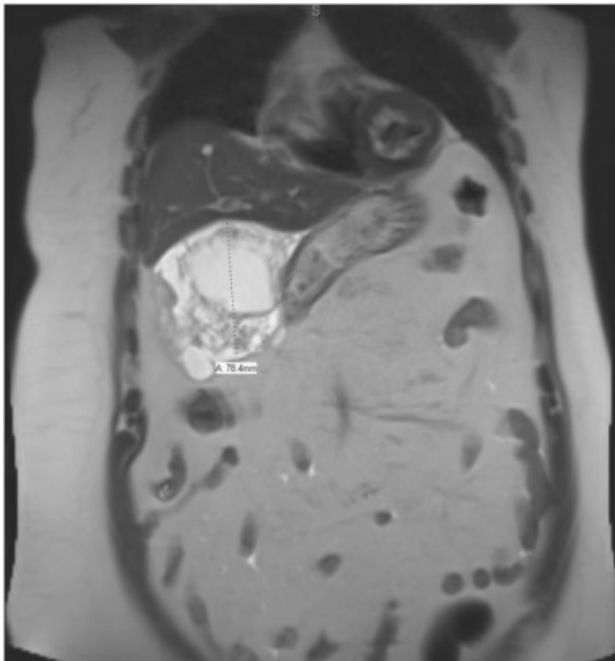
Transverse imaging of an abdomen and pelvis MRI demonstrating a relatively well-defined, multilobulated, predominantly cystic lesion measuring (17 cm x 8 cm). There's an evidence of thick internal septations and soft tissue components seen occupying the right subhepatic space.
